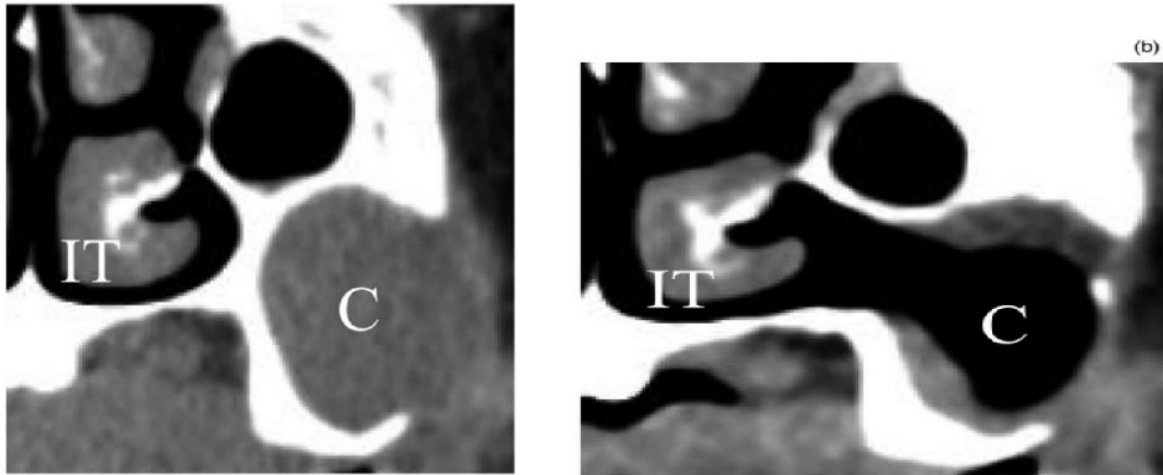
Computed tomography scan (a) before and (b) after inferior meatal antrostomy with a mucosal flap, in patients with a maxillary mucocele. IT = inferior turbinate; C = cyst
